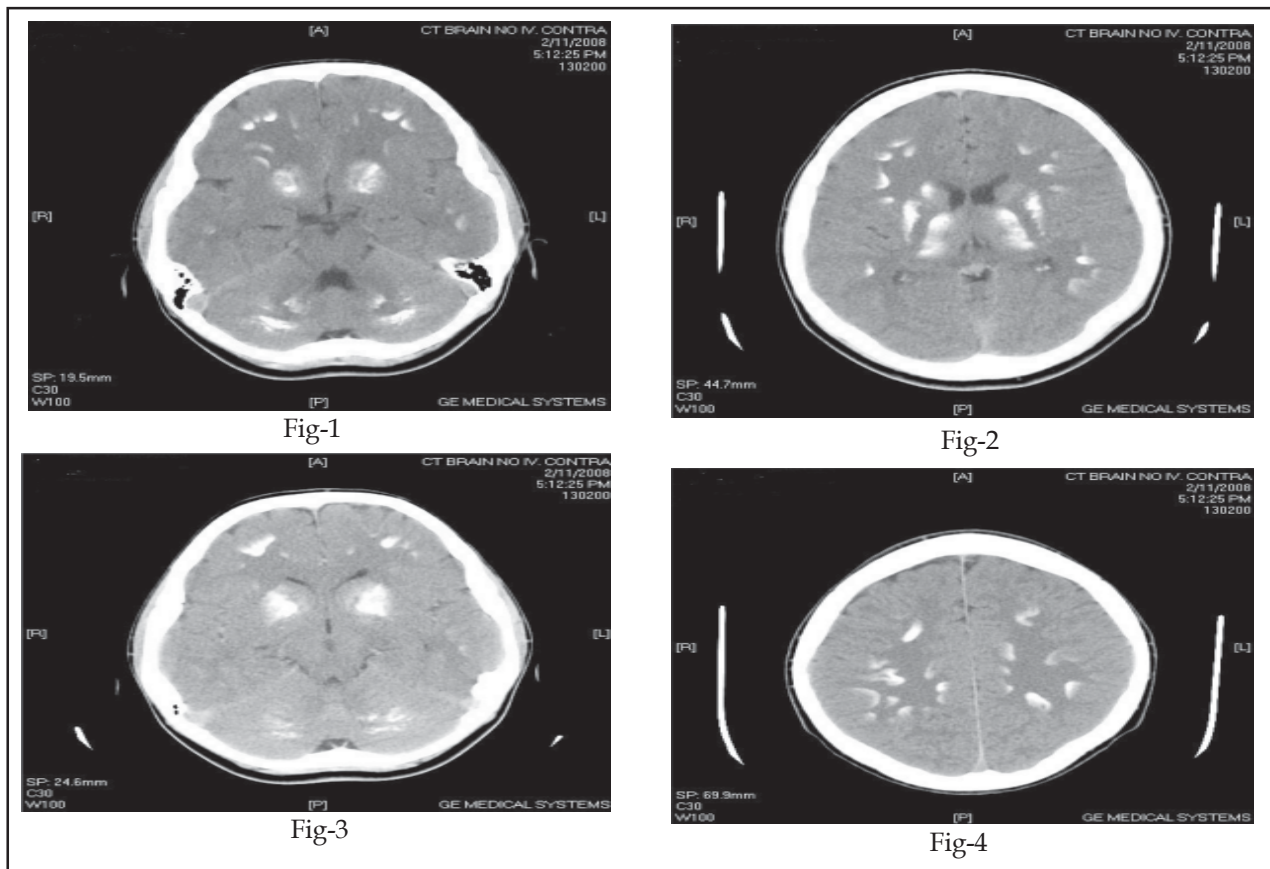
Extensive calcification of brain showing in CT brain at different levels
